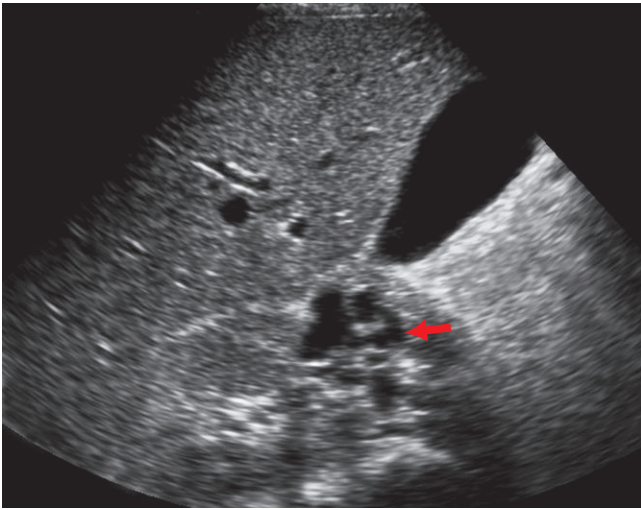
The transverse gray scale sonographic image shows multiple tortuous, tubular channels in the vicinity of the main right renal vein (arrow). The normal renal vein cannot be visualized.
